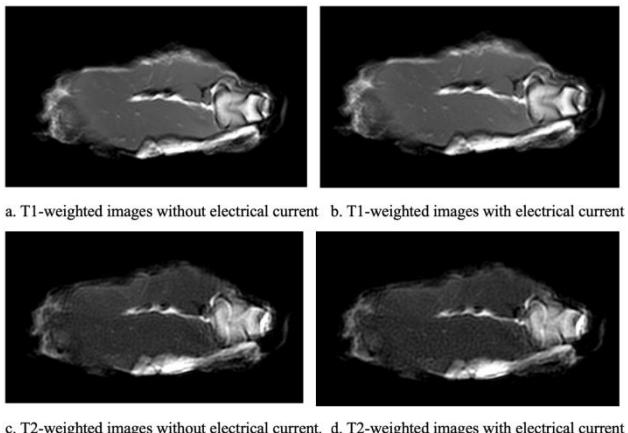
Images here shown different tissue image intensity with and without electrical current injection. Both T1-weighted and T2-weighted images experienced tissue signal intensities changes due to electrical current introduction, with T1-weighted images appeared darker (lower signal intensity) and T2-weighted images appeared brighter (higher signal intensity)
